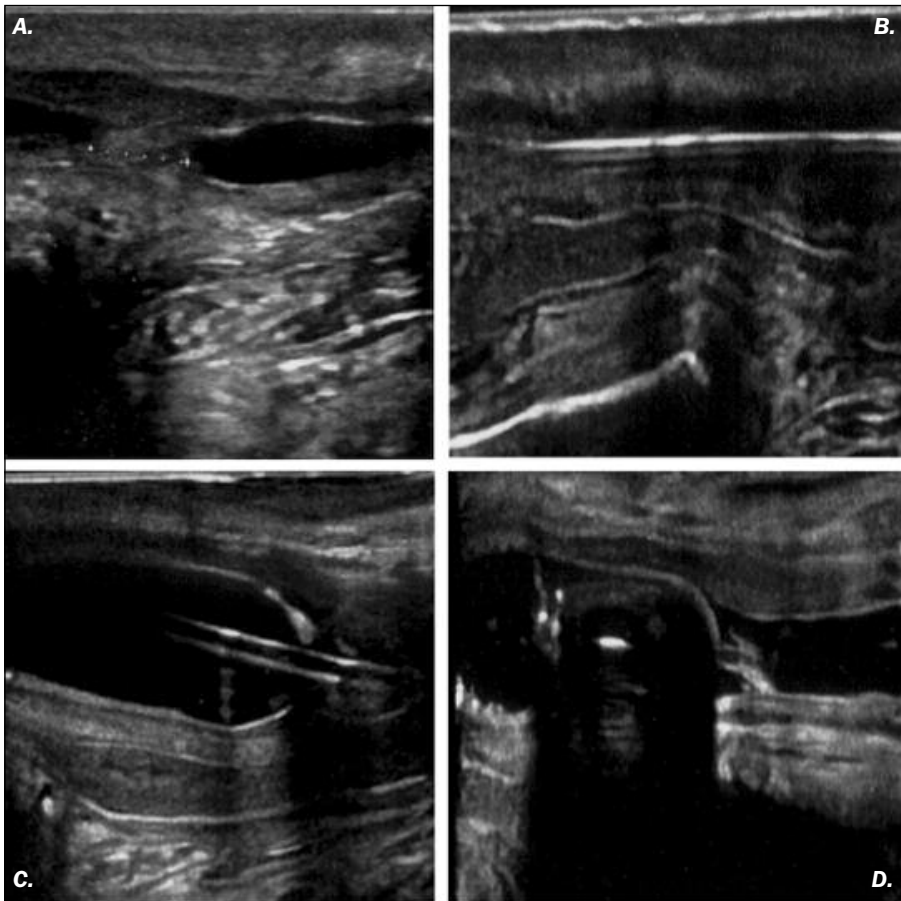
Ultrasound evaluation of anterior urethral stricture before coated balloon dilatation (DCB) (a); a guide was introduced through the stenosis to perform dilatation (b); DCB was performed in correspondence of the stenosis (c and d).*
